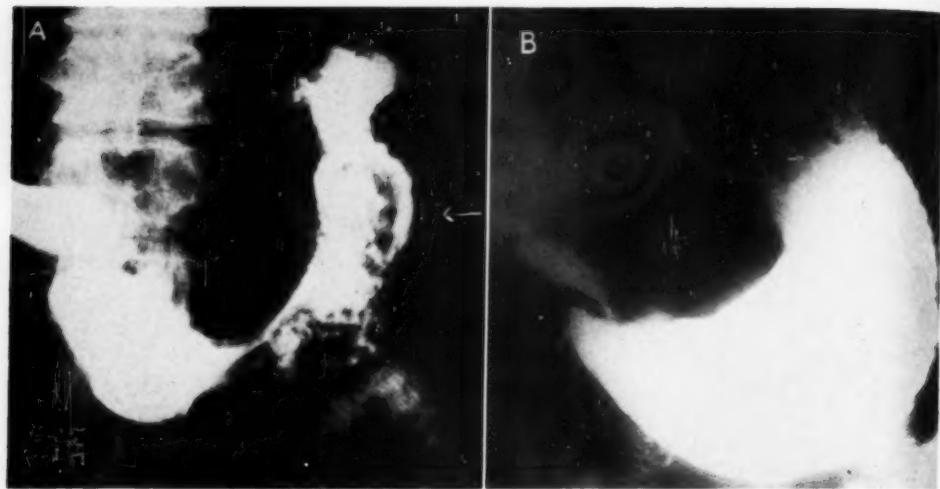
Case 9: A. Roentgenogram taken with half dose of barium. Note central filling defect at arrow; also ulcer niche at prepyloric part of lesser curvature. B. Roentgenogram taken with full dose of barium. The filling defect is completely obliterated by the excess of barium. Note ulcer niche on prepyloric part of lesser curvature.
